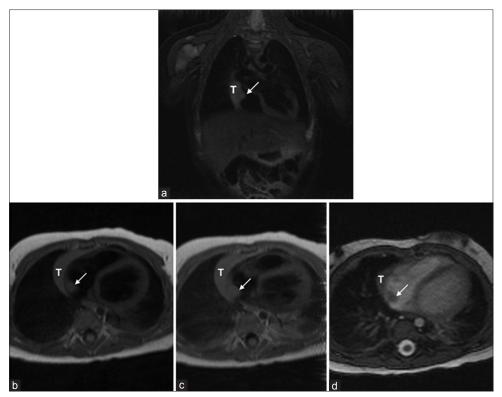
A mass in the right atrium is observed in the magnetic resonance imaging (arrow): isointense to myocardium on coronal T2-weighted STIR (a), slightly hyperintense on axial T1 (b), and on delayed contrast-enhanced T1-weighed image (c). Bright blood axial SSFP sequence (d). T: Thymus
